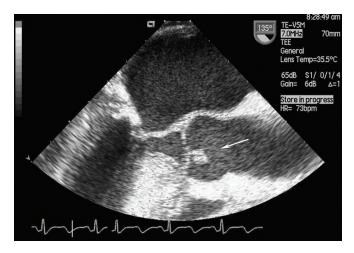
A, Transesophageal echocardiographic long-axis view of the aortic root showing a pedunculated free, mobile papillary tumor (0.6 \times 0.7 cm). B, Papillary fibroelastoma (0.6 \times 0.7 cm) in physiological saline solution showing the anemone-like appearance.
